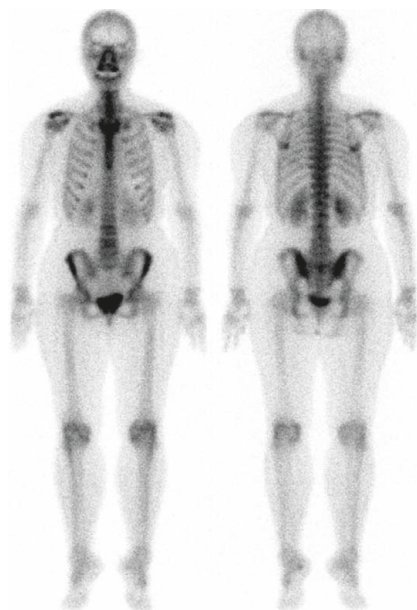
A patient with “normal” bone scintigraphy. No definite bony destruction events are present in this Tc-99m MDP whole body bone scintigraphy scan of a patient with prostate cancer.
